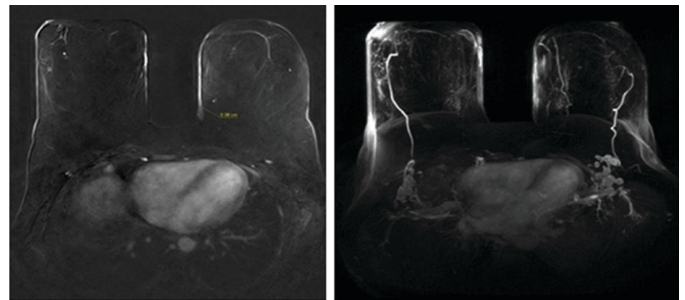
Contrast-enhanced MRI and MIP images revealed a patchy area of skin thickening and hyperenhancement at both lower medial breasts more pronounced at left lower medial posterior breast with a maximum thickness of 0.38 cm.
